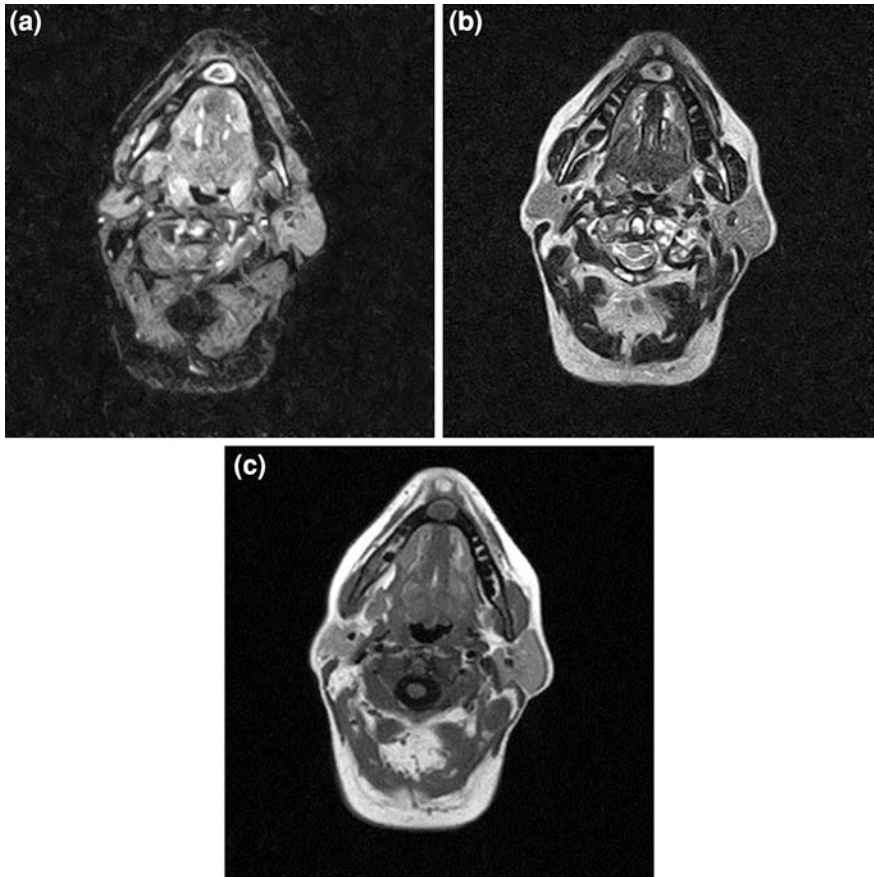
MRI axial STIR (a) T2 (b) and T1 (c) weighted images demonstrating typical behavior of bisphosphonate osteonecrosis of mandibular bone (*thin arrow*)
